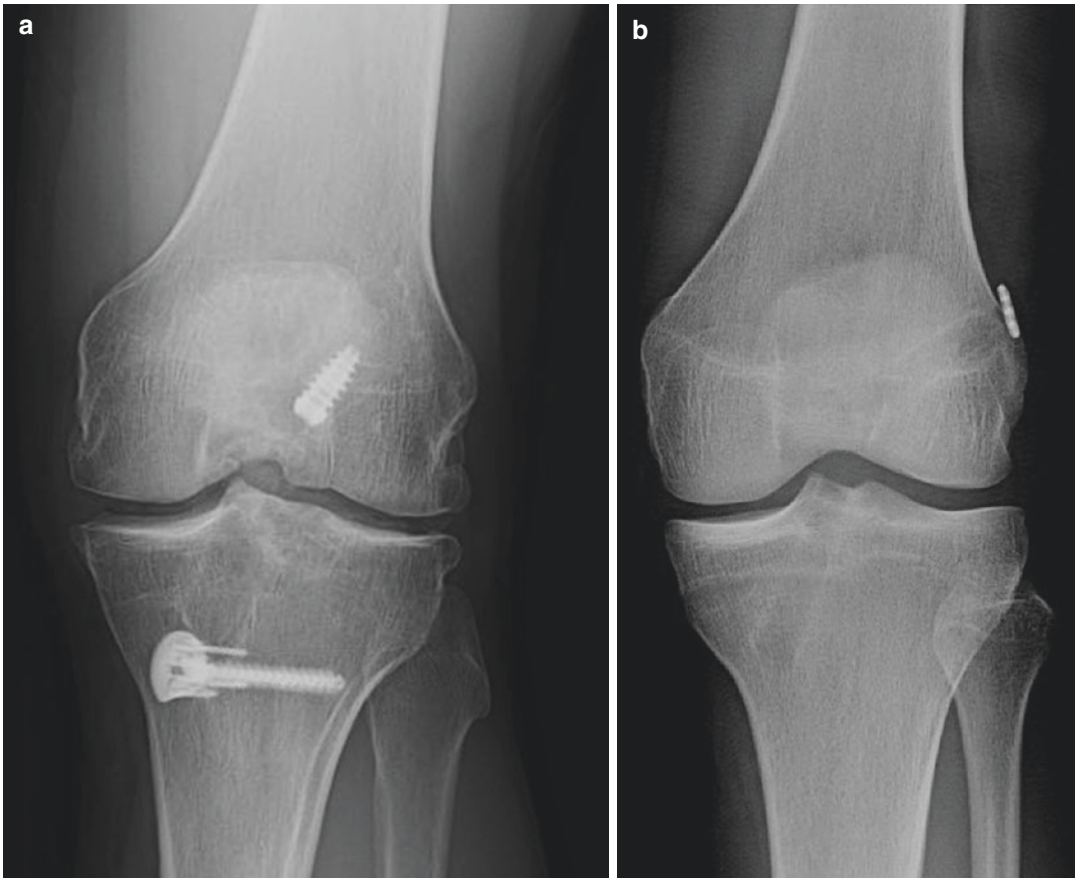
Comparison of non-anatomic and anatomic ACLR on long-term OA prevalence. (a) Ten-year follow-up X-ray of non-anatomic ACLR performed by transtibial drilling demonstrating osteoarthritic changes, including
